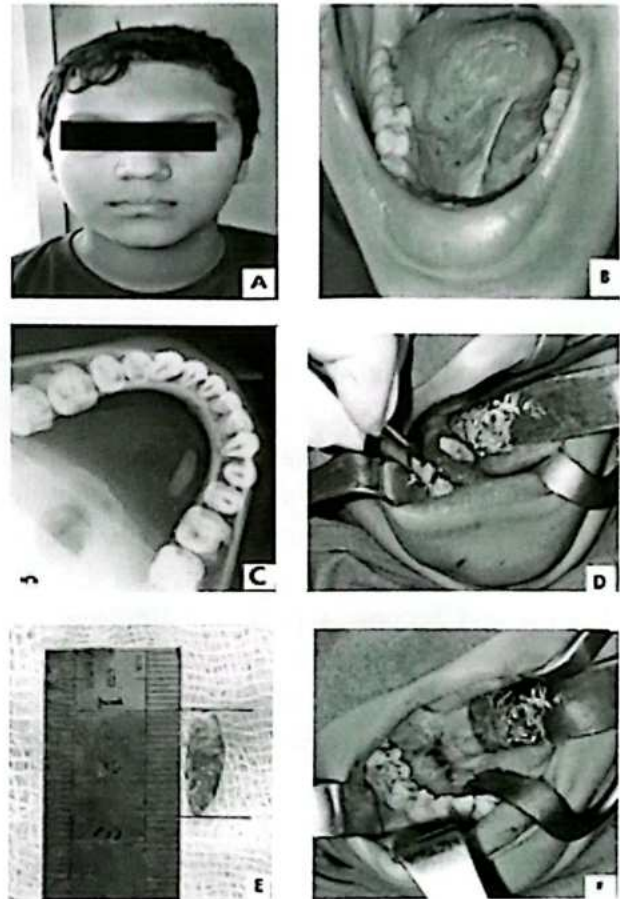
(A) Patient's profile; (B) swelling in the floor of the mouth; (C) mandibular occlusal radiograph showing sialolith (D) sialolithotomy (E) excised sialolith (F) suturing of the defect.
